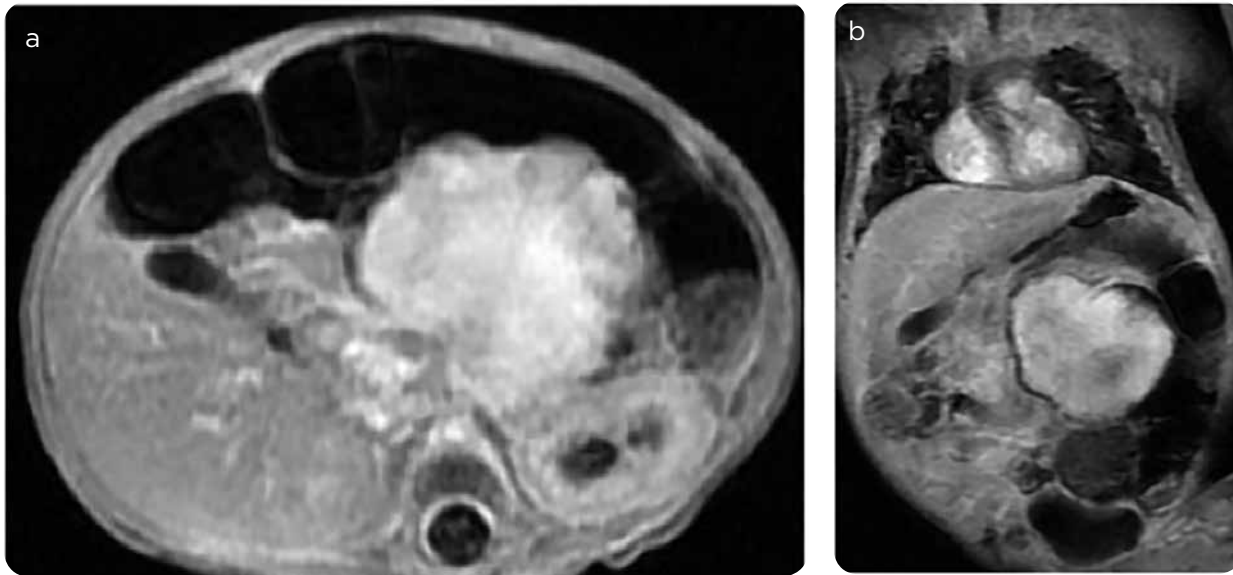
Abdominal MRI. a) Sequence with T1 information, axial, with contrast medium, b) Sequence with T1 information, coronal, with contrast medium. An oval mass with well-defined contours is identified, located in the mesentery, with important enhancement after the application of the contrast medium.
